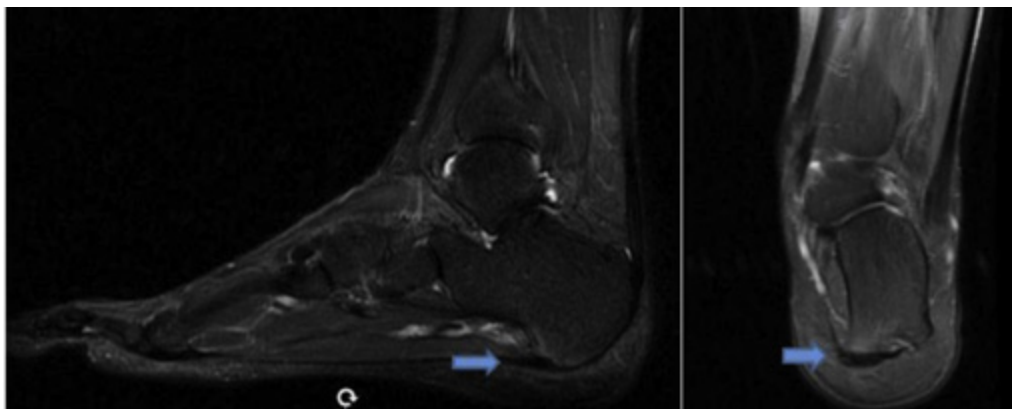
Evaluation of the plantar fascia thickness by magnetic resonance imaging on sagittal (5.4 mm) and coronal (5.6 mm) planes. Arrows indicate measurement location.
